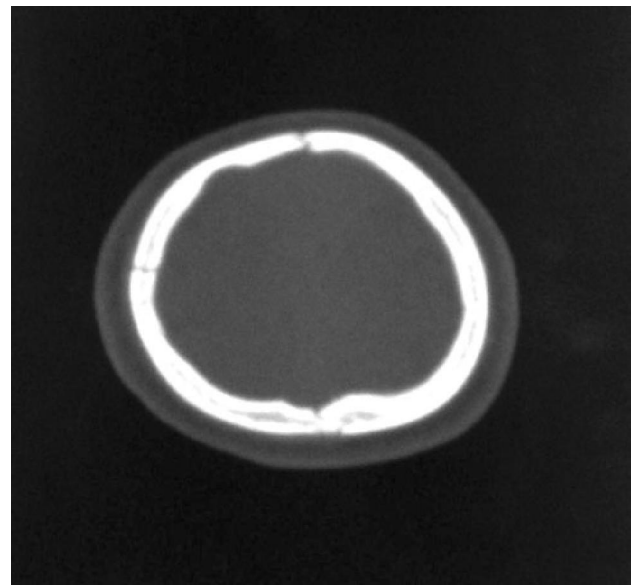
Axial CT scan at bone window level showing linear fracture of right frontal bone.
